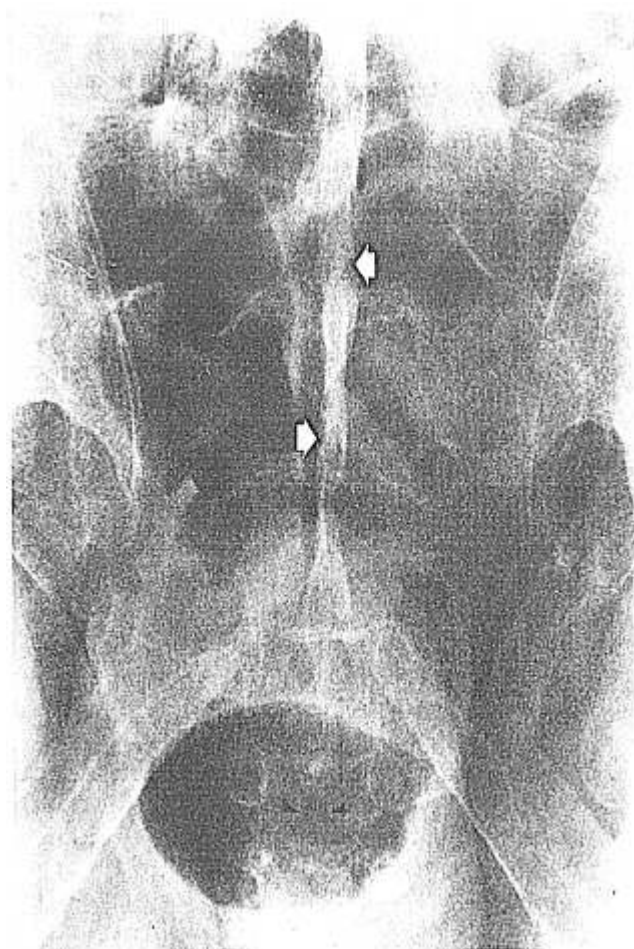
Anteroposterior view of the sacrum with 25° cephalic angulation. Radiographs of the sacrum demonstrate total ossification of sacral interspinous and supraspinous ligaments (*arrows*). The caudal foramen is shown to be open and noncalcified (*arrowheads*).
